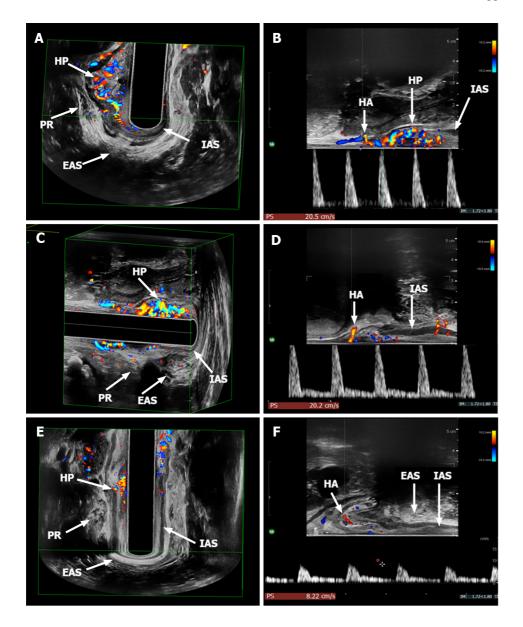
Endoanal ultrasound. A-D: Preoperative endoanal ultrasound performed by a linear endocavitary transducer (3DX14L4-9038, BK Medical, Herlev, Denmark). Three-dimensional ultrasound with color Doppler showing grade 3 hemorrhoidal plexus (HP) at 11 o'clock position (A); The mean hemorrhoidal artery (HA) systolic peak velocity was 20.5 cm/s (B); Three-dimensional ultrasound with color Doppler showing grade 3 HP at 1 o'clock position (C); and the mean HA systolic peak velocity was 20.2 cm/s (D); E and F: Endoanal ultrasound at 1-mo follow-up. Three-dimensional ultrasound with color Doppler showing the regression of HP at 1 o'clock position (E); and the reduction of the mean HA systolic peak velocity (8.22 cm/s) (F, same case of Figure A and B). EAS: External anal sphincter; IAS: Internal anal sphincter; PR: Puborectalis muscle.
